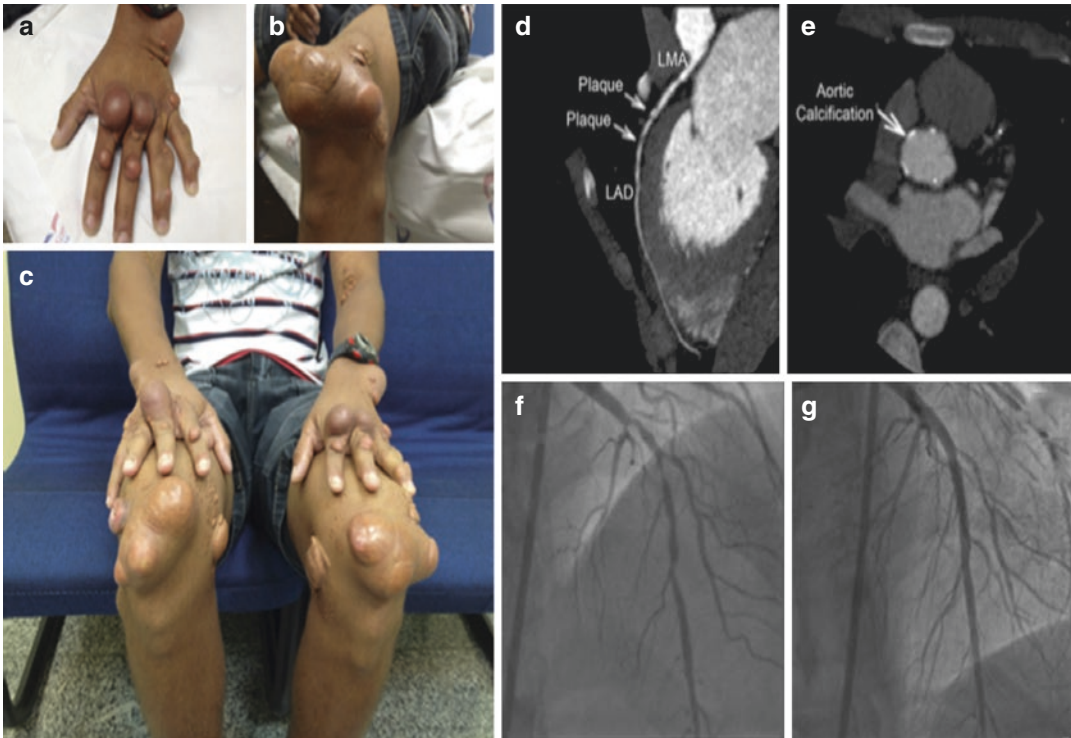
Giant tendinous xanthomas and severe subclinical coronary atherosclerosis in an asymptomatic 20-year-old individual with HoFH that had never been treated until diagnosis. Patient was asymptomatic, had an untreated LDL-C of 710 mg/dL (18.2 mmol/L), genetic study showed homozygosity for a pathogenic variant on the *LDLR* Genotyping (A540T in exon 11). Giant tendon xanthomas on hands and knees (a–c), computed tomography angiography showed a plaque in the proximal left anterior descending (LAD) coronary artery causing severe
